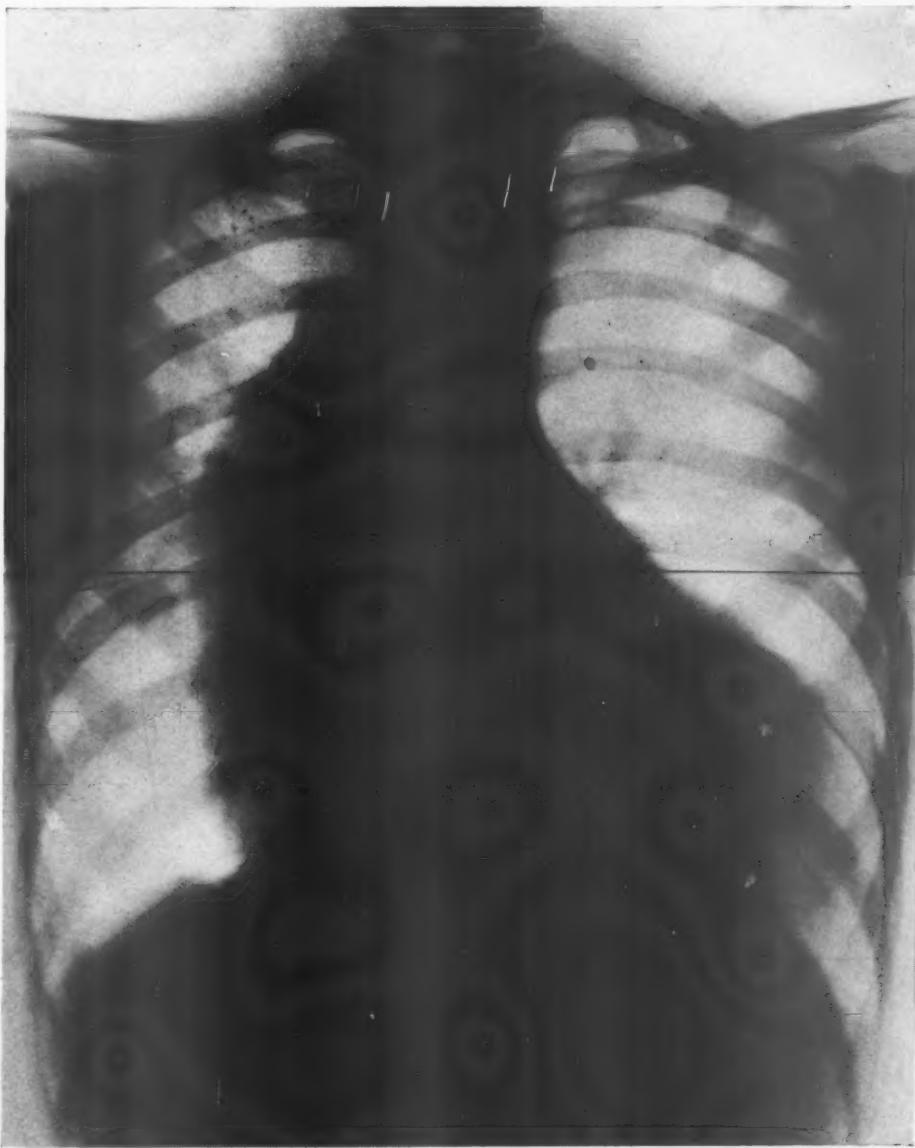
Roentgenograph taken of the heart and aorta during life of the authors' case (E. B.), showing enormous enlargement of the left ventricle, great broadening of the aortic shadow to the right marking the site of the saccular aneurysm of the ascending arch, and absence of the third left (aortic) arc indicating excessive narrowing at the point of coarctation. (From the Medical Service of the Royal Victoria Hospital, Montreal.)
